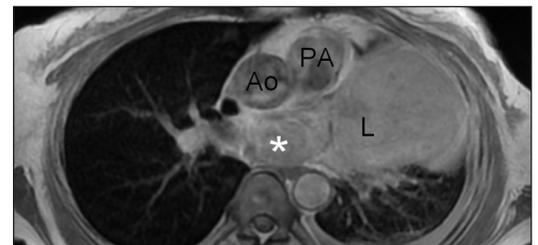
Axial T1 post-gadolinium MRI images of the heart demonstrates enhancement in the left atrial mass (*), a finding that is consistent with tumor rather than thrombus. Also seen in the left lung mass, left lung collapse, left pleural effusion.
